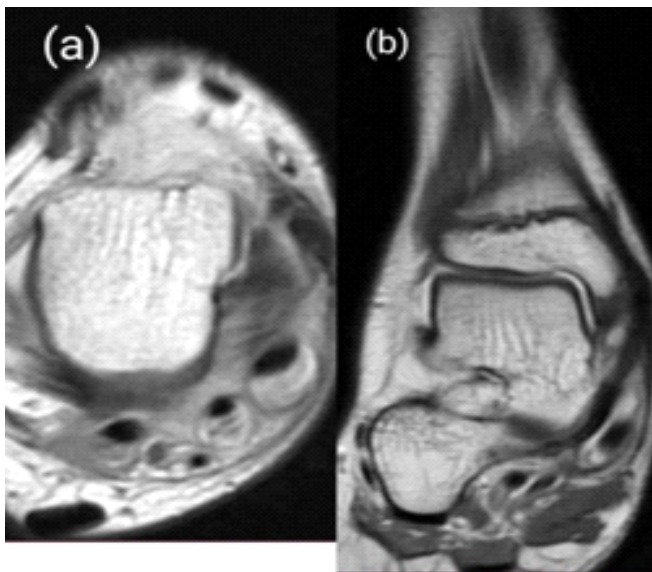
(a) T1 shows axial cut of ankle with tenosynovitis of tibialis posterior tendon, (b) T1 image of magnetic resonance imaging ankle in coronal view showing tenosynovitis of tibialis posterior with no obvious evidence of foreign body.
